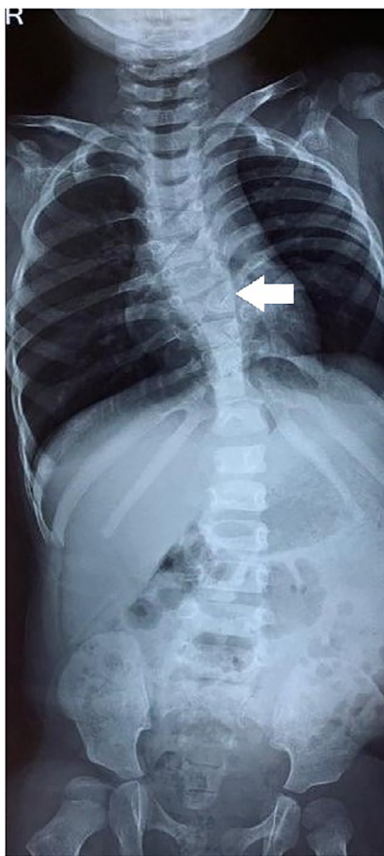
Antero-posterior radiograph of spine. There is mild levoscoliosis centered in dorsal spine. D7 butterfly vertebra is seen.
